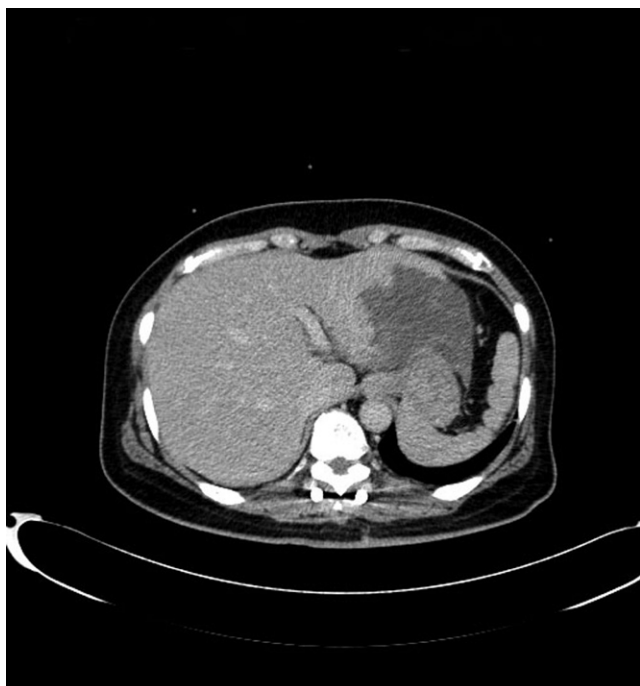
A computed tomographic image of the abdomen demonstrates a left intrahepatic mass, which was found to be a cholangiocarcinoma.
